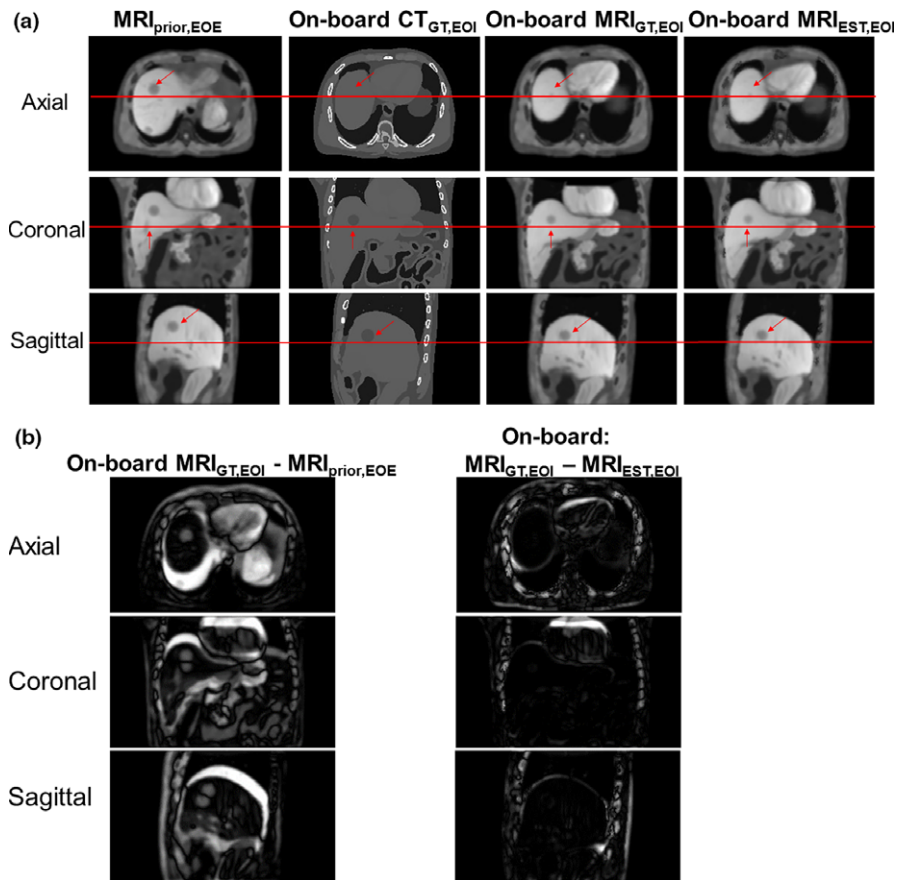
(a) The columns from left to right are the following.  $MRI_{prior}$  at EOE phase, ground-truth CT at EOI phase, ground-truth on-board MRI at EOI phase and estimated on-board MRI at EOI phase for XCAT Scenario 2. The rows represent axial, coronal, and sagittal views, respectively. The horizontal line and arrows indicate areas for comparison. (b) Subtraction images for axial, coronal, and sagittal images shown in (a). [Color figure can be viewed at wileyonlinelibrary.com]
